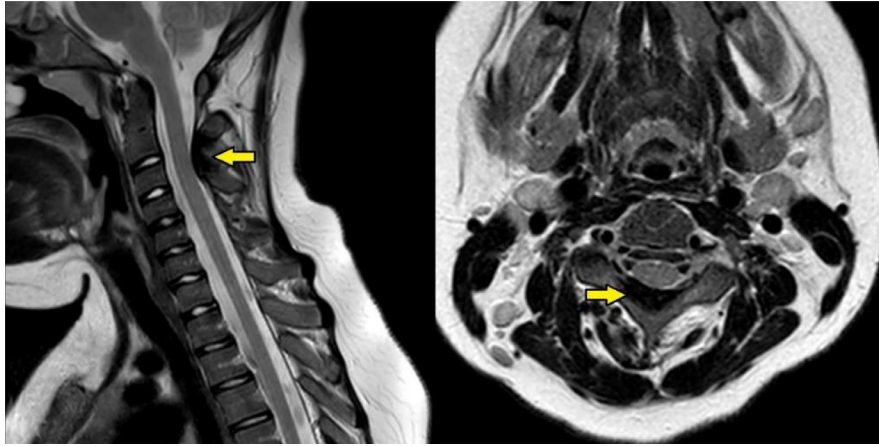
Sagittal and axial T2-weighted MRI of the cervical spine reveals extradural dark signal within the posterior spinal canal from C2-C4.
